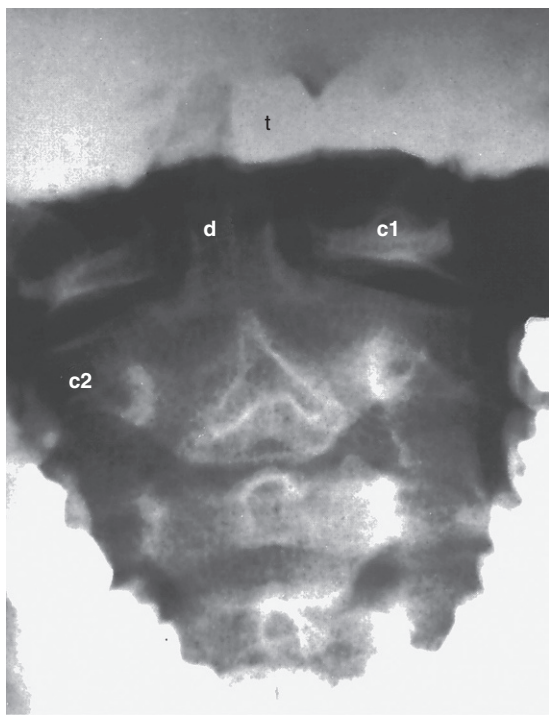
Open-mouth or odontoid radiograph of normal cervical spine. c1, Anterior arch of C1; c2, body of C2; D, Dens axis (C2); t, teeth. (From Ovassapian A: *Fiberoptic Airway Endoscopy in Anesthesia and Critical Care*. New York, Raven Press, 1990, p 37.)
